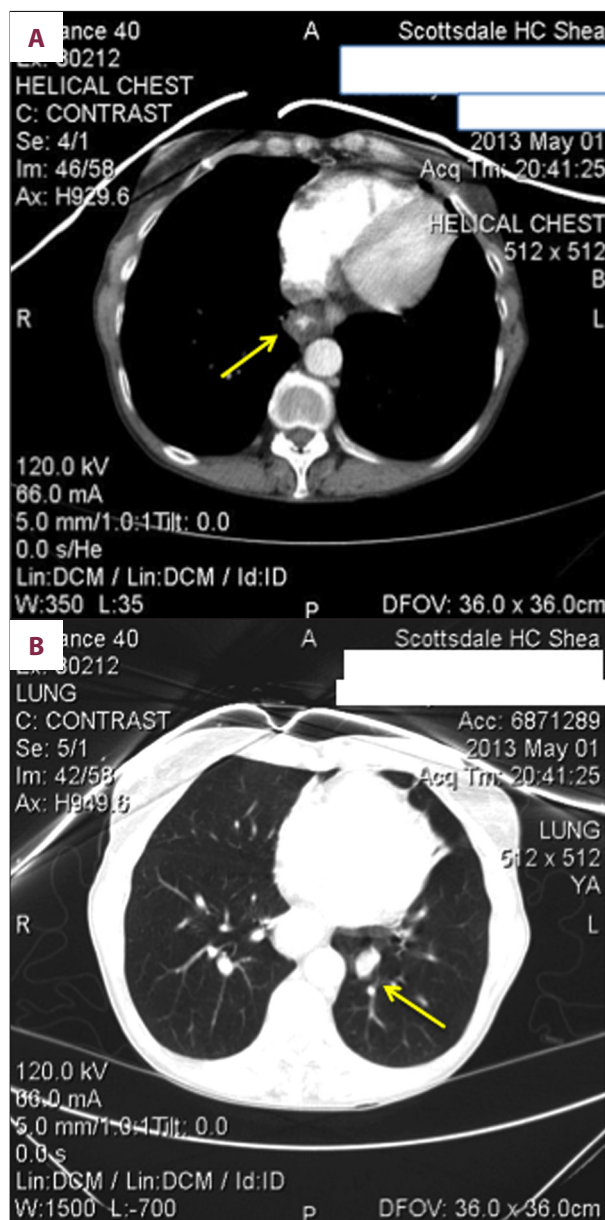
Radiographic study by chest CT scan. (A) CT showing a focal thickening of the mid to distal esophagus. (B) CT showing a new 1.7-cm loculated soft-tissue lesion in the left lower lobe.
